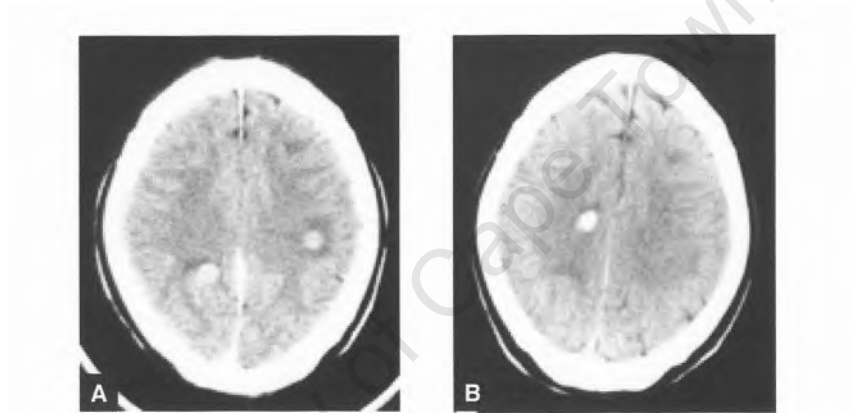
Axial CT scan showing ring-enhancing lesions with surrounding low density (a). Follow-up CT one day after biopsy shows a small haematoma in the deep white matter, some distance away from the planned target.
